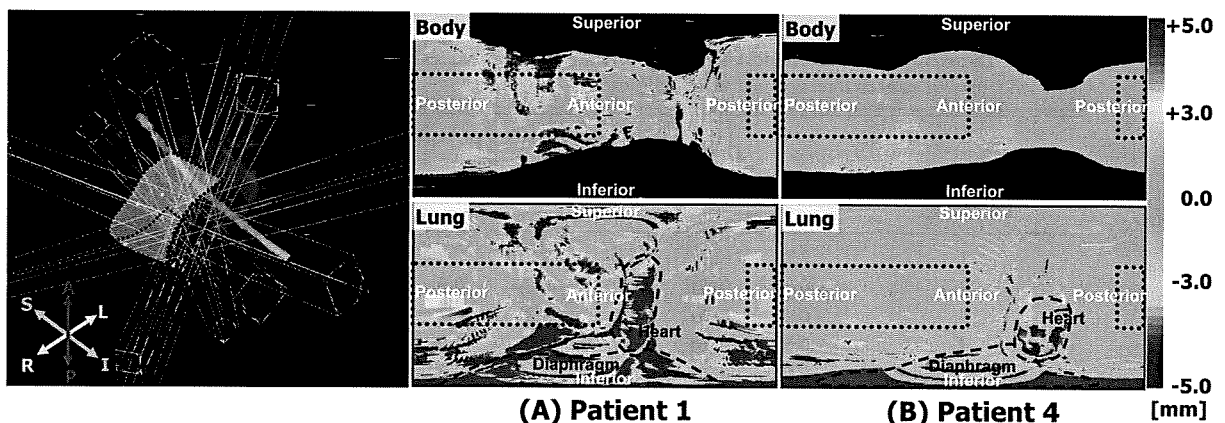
Maps showing the error in radial distance from the tumor centroid to the body (upper) and lung (lower) surfaces for virtual versus actual 4D-CT images. Regarding radial distance error for the body, the region of directions in which a given ray passed through the top and bottom plane of CT images is blacked out (invalid values). A dotted rectangle (green-shaded area in the 3D view) indicates the area through which clinically available beams pass.
